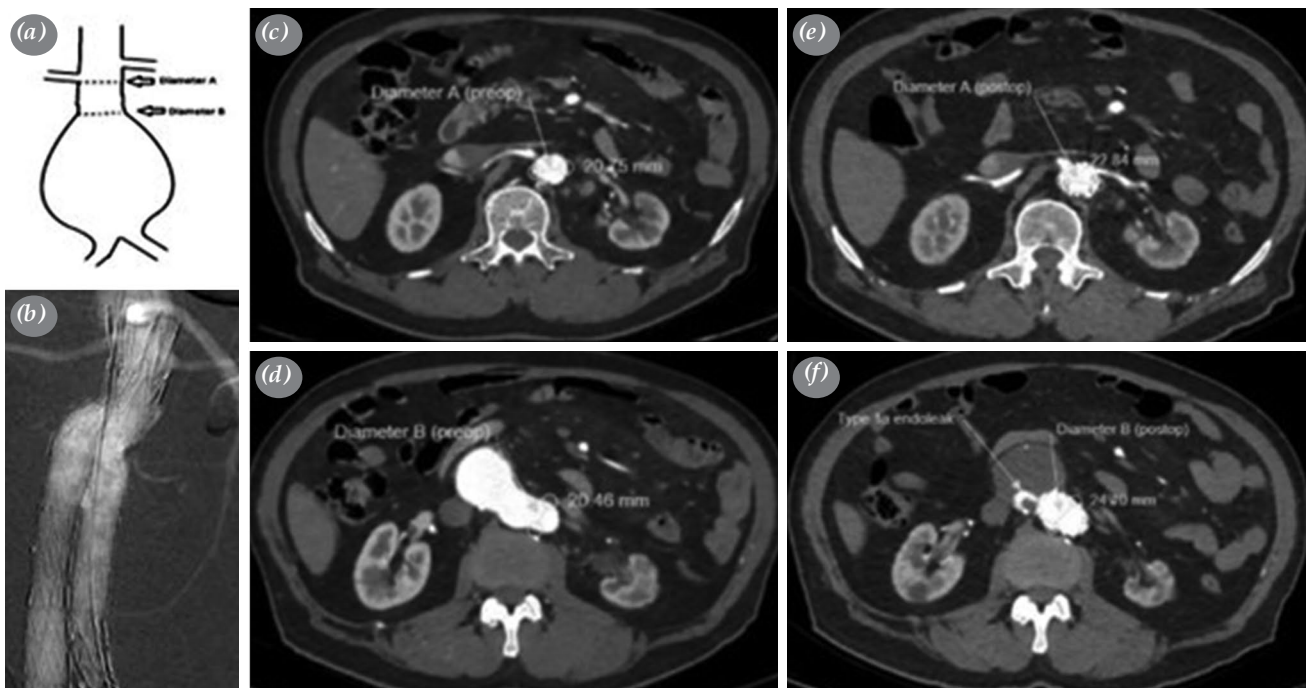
(a) Preoperative measurements with assessing the CT angiography images. (b) %20 oversizing with 24 mm EVAR graft. (c) Preoperative measurements of Diameter A; (d) Preoperative measurements of Diameter B; (e) Postoperative measurements of Diameter A. (f) The enlargement of Diameter B after postoperative 6th month CT control and detected type 1a endoleak.
